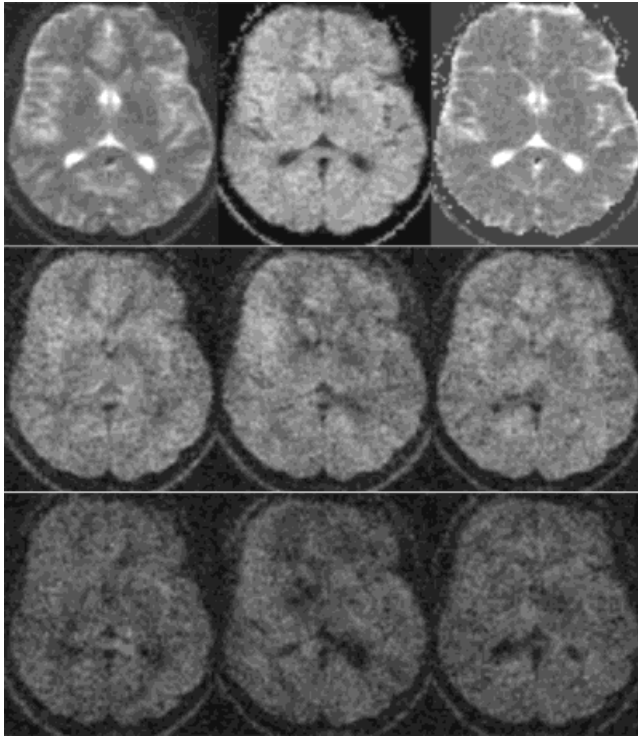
DW single-shot STEAM MRI of the human brain. Top: Single-shot image without DW (left), calculated isotropic DW image at  $b = 1000 \text{ sec mm}^{-2}$  (middle), and calculated ADC map (right). Middle: Single-shot DW scans in three orthogonal orientations at  $b = 490 \text{ sec mm}^{-2}$ , and bottom: at  $b = 1000 \text{ sec mm}^{-2}$ . The images represent a 6-mm-thick section at  $2.0 \times 2.0 \text{ mm}^2$  resolution ( $80 \times 128$  matrix,  $160 \times 256 \text{ mm}^2$  FOV, flip angle  $11^\circ$ , imaging time 559 msec).
